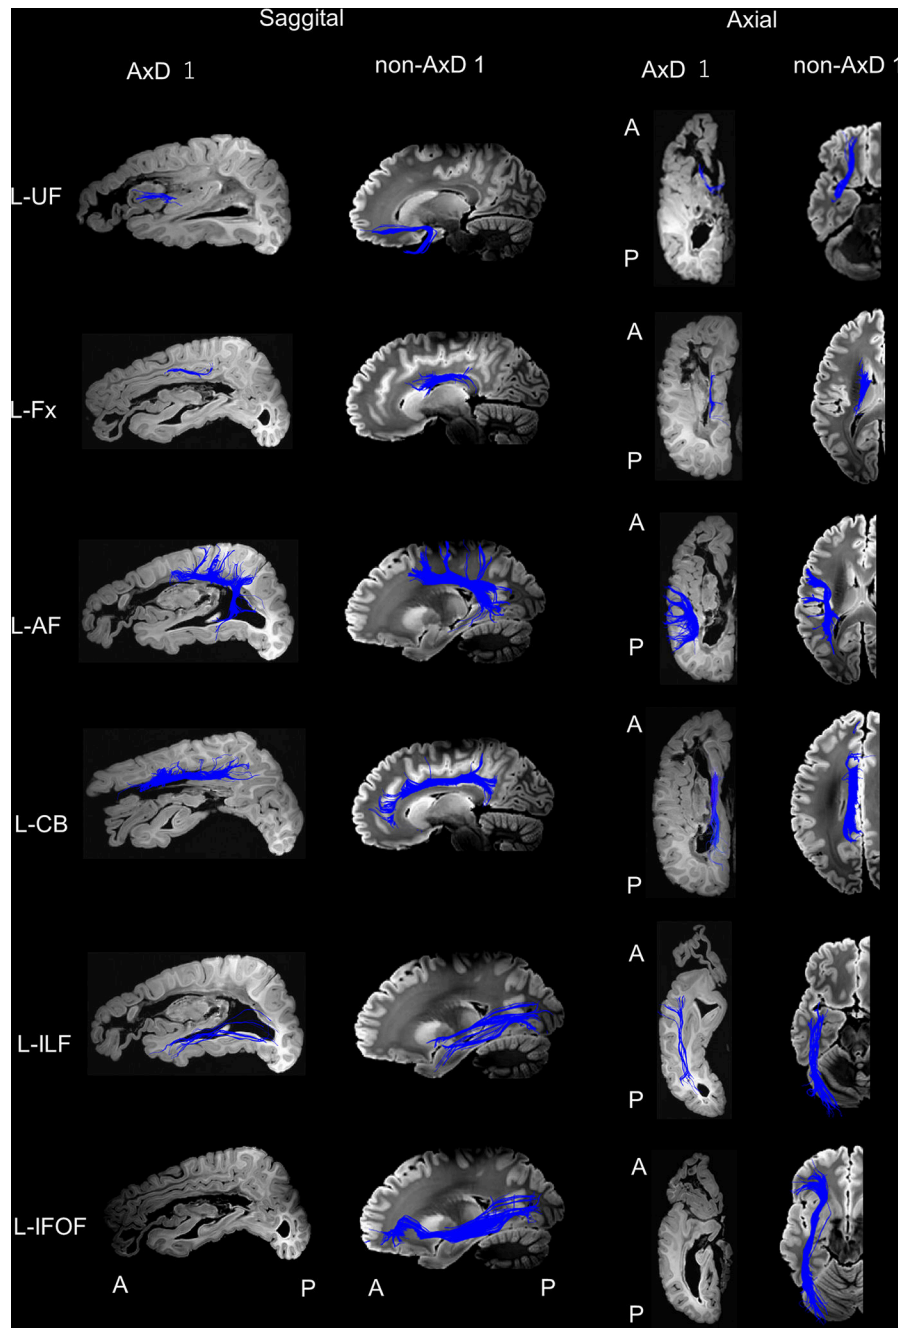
High-angular resolution diffusion MRI tractography showing major cortico-cortical pathways of the left hemisphere of a 9-year-old boy with Alexander disease (AxD 1) and a 9-year-old neurotypical boy (non-AxD 1). Abbreviations: A, anterior; AF, arcuate fasciculus; CB, cingulum bundle; Fx, fornix; IFOF, inferior fronto-occipital fasciculus; ILF, inferior longitudinal fasciculus; L, left; P, posterior; UF, uncinated fasciculus.
